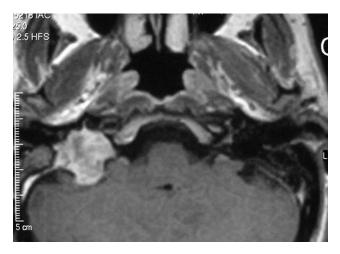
Axial T1-weighted MRI scan with gadolinium of a chondrosarcoma centered on the right jugular foramen demonstrating heterogeneous enhancement (case 4).
